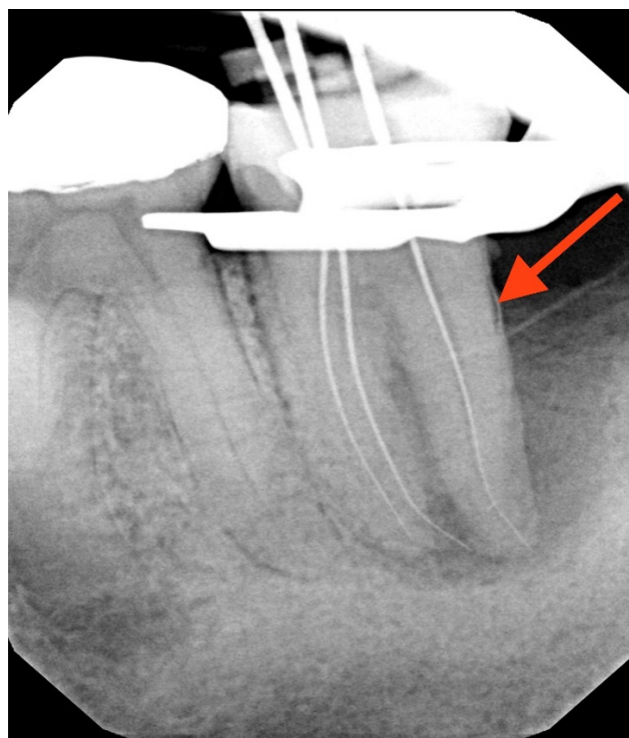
Working length radiograph showing radiopaque fragment consistent with a cemental tear along distal root (red arrow).
